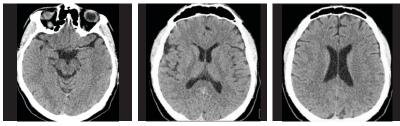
Non-contrast CT scan before iv thrombolysis showing left MCA hyperdensity, sulcus effacement
